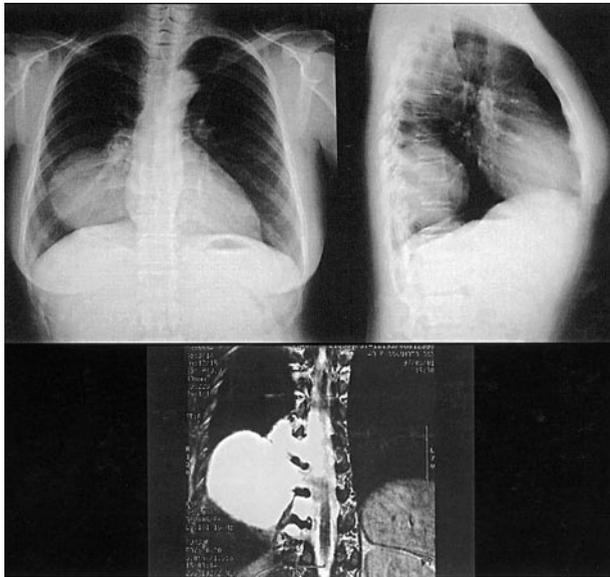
Chest radiograph on hospital admission shows a round, well-circumscribed shadow 10 cm in diameter in the lower right chest (*top left*). A right lateral view shows a mass in the posterior mediastinum (*top right*). MRI (*bottom*) clearly demonstrated paravertebral cysts communicating with the vertebral canal.
